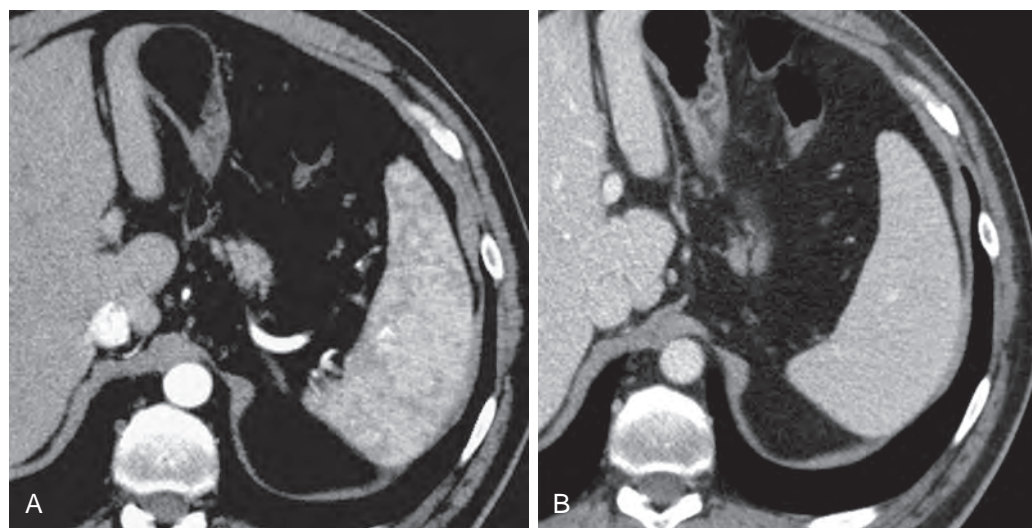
Normal pattern of splenic enhancement on multidetector CT. A. Arterial phase shows a mottled enhancement pattern due to differential flow of contrast material in the red and white pulp of the spleen. B. Portal venous phase shows uniform splenic enhancement.
